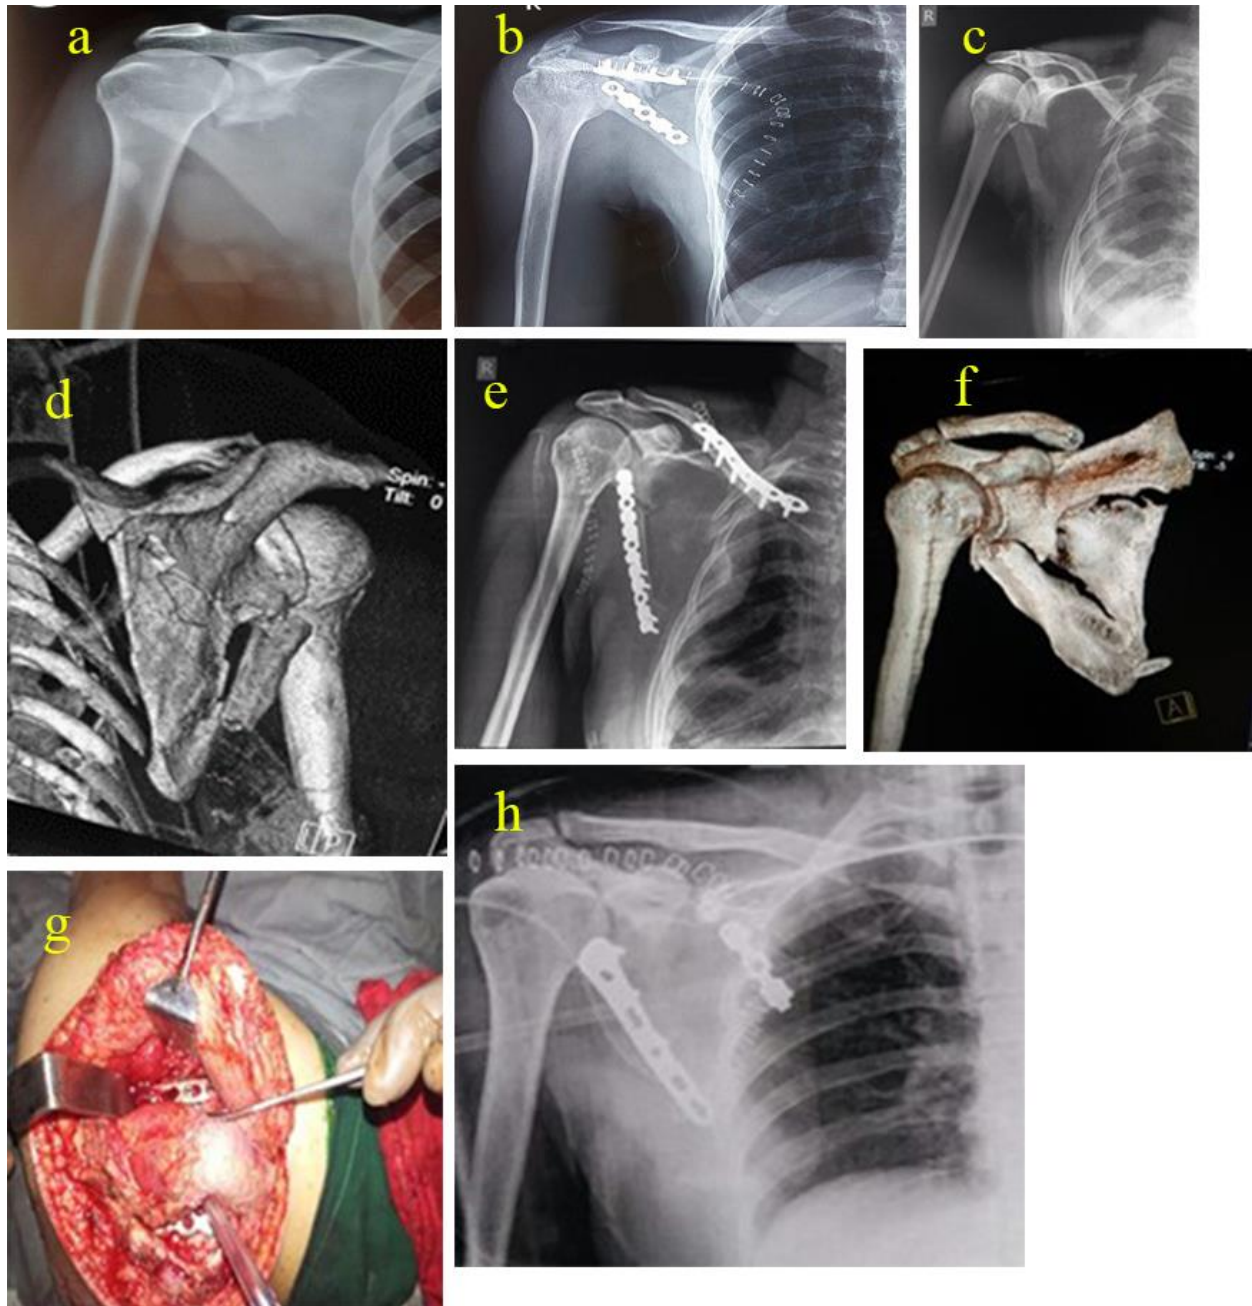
Complete operative procedure (a): Before operation X-ray, (b): After operation X-ray, (c): Before operation X-ray, (d): CT scan before the operation, (e): After operation X-ray, (f): CT scan before the operation, (g): During operation, (h): After operation X-ray
